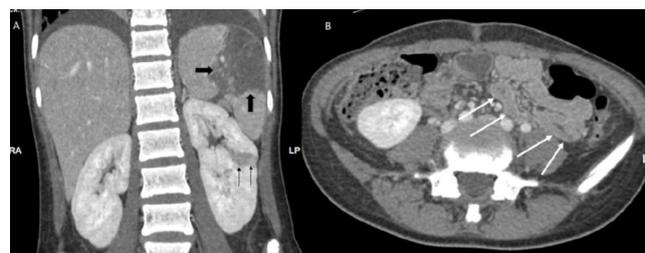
Contrast-enhanced CT scan of the abdomen in coronal reconstruction (A) demonstrating a wedge shaped geographic non-enhancement of the spleen (thick black arrows) and left kidney (thin black arrows) consistent with infarctions; and axial reconstruction (B) demonstrating small bowel wall thickening (white arrows) in keeping with ischaemia.
